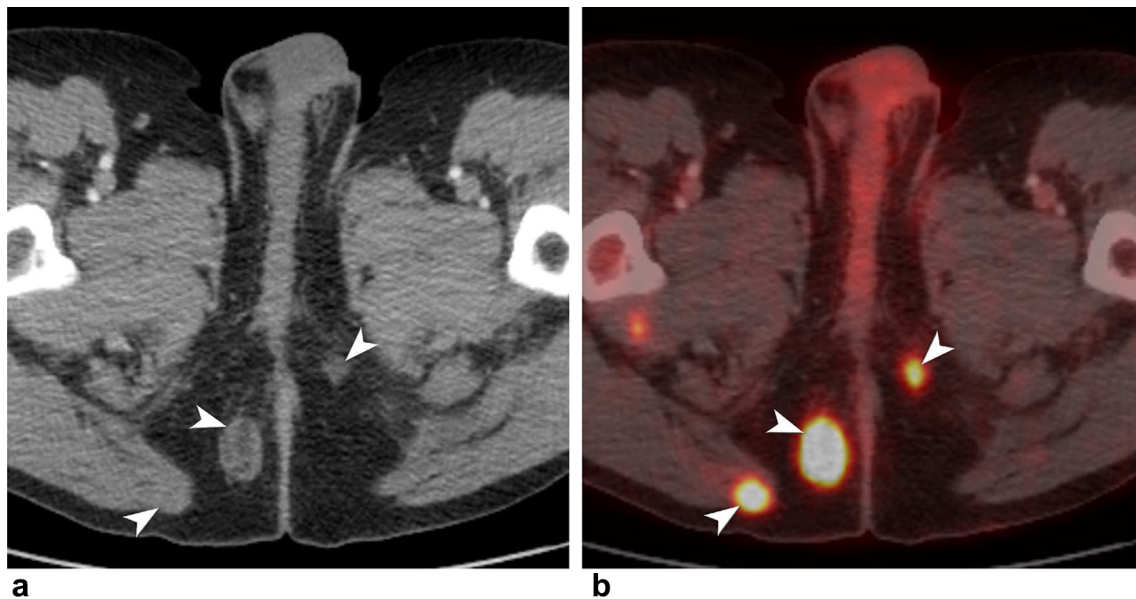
75-year-old male with lymphoma. Axial contrast-enhanced CT (a) and PET/CT (b) images of the pelvis showing multiple lymphomatous metastatic masses (white arrowheads) within the bilateral ischioirectal fossae with intense FDG uptake in the PET/CT image (b)
